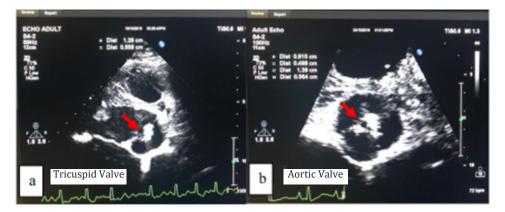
Echocardiography Showed Vegetation at Tricuspid Valve in RV Inflow View (a), Vegetation at NCC of Aortic Valve in Short Axis View (b)
